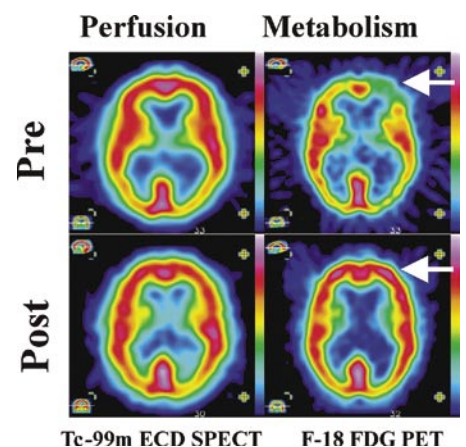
Use of PET and SPECT imaging revealed a mismatch in luxury perfusion as hypometabolism in the left frontal region (arrows) that was alleviated with endoscopic third ventriculostomy (ETV) surgical treatment.
